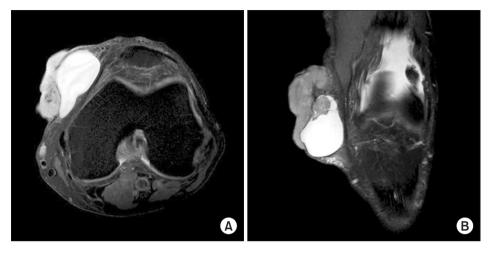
(A) Preoperative T2-weighted axial magnetic resonance imaging (MRI) shows the left knee mass. The mass consisted of both solid and cystic components. The solid component is markedly hyperintense. (B) Preoperative T2-weighted coronal MRI shows the left knee mass.
